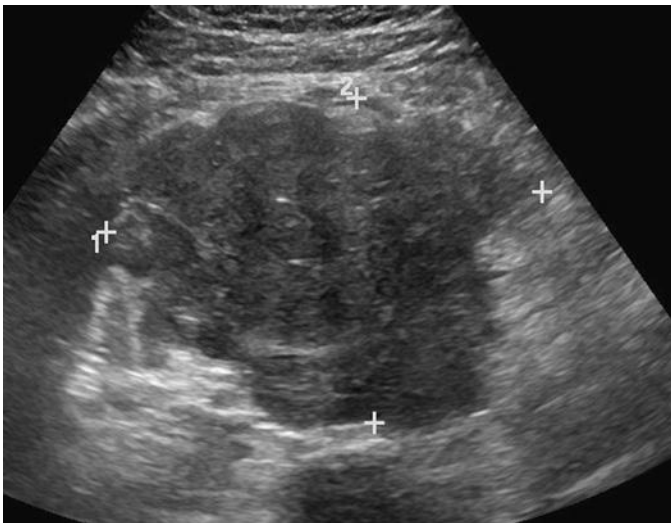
Ovarian dysgerminoma. Completely solid ovarian mass (*calipers*), with an irregular lobulated external contour, seen in a 20-year-old woman. The combination of sonographic appearance and patient age is suggestive of this diagnosis.
